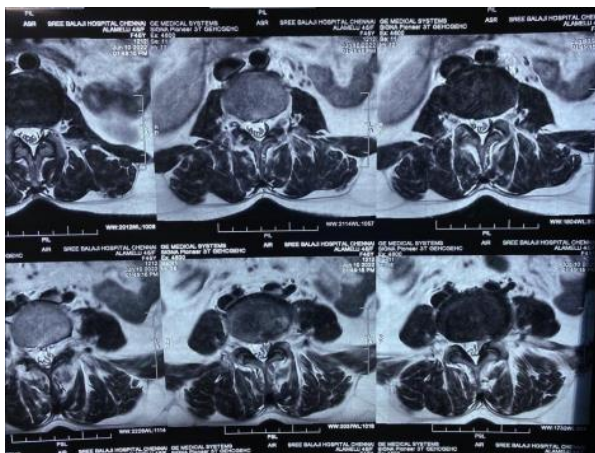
PREOPERATIVE MRI AXIAL VIEW
